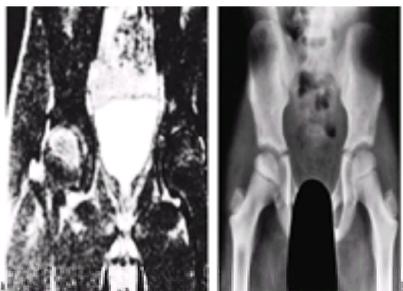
A: Magnetic resonance image of a 7-year, 4-month-old boy with sickle cell anemia. Patient complained of pain in the right hip. The T2-weighted image is consistent with avascular necrosis of the right femoral head. On other views, abnormal signals also were present in the left femoral head, although not to the degree seen in the right femur. B: Anteroposterior radiograph of the pelvis 5 months later demonstrates sclerosis of the lateral and inferior margins of the epiphysis, consistent with the creeping substitution healing of osteonecrosis. Patient had been maintained in an abduction brace. (Adapted from ref. 79, with permission.)
